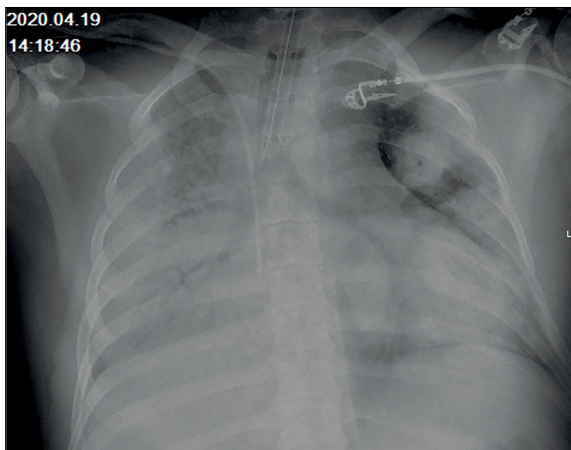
Chest x-ray with bilateral infiltrates and positive air-bronchogram-sign
